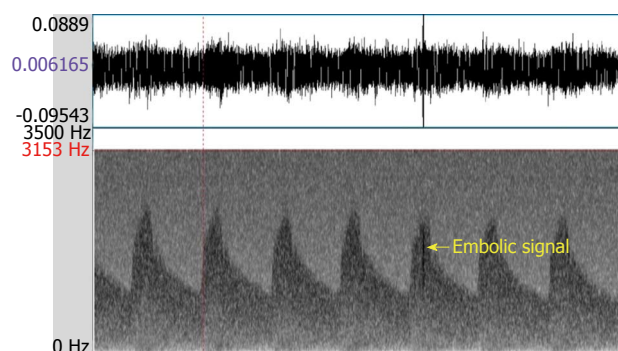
Embolic signal. The NICOLET Pioneer transcranial Doppler 4040 Doppler Waveform Analyzer was used.
